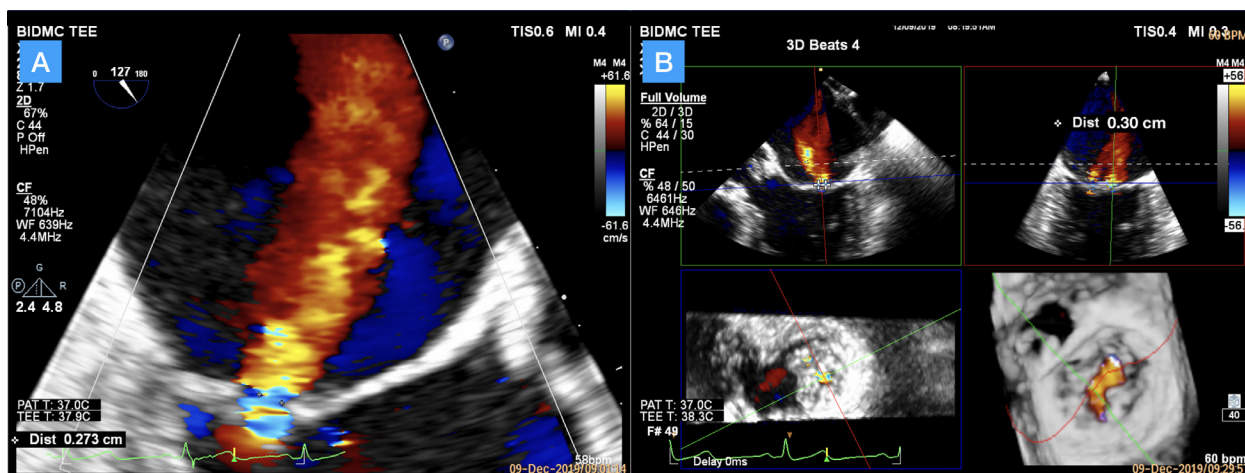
(A) Midesophageal long axis view (zoom) of regurgitant mitral valve using vena contracta (VC) of a mitral regurgitation (MR) jet measured 0.27 cm to grade severity of mitral regurgitation. (B) Transesophageal echocardiogram imaging of a MR jet using 3-dimensional multiplanar reformatting to evaluate vena contracta measured 0.3 cm.
